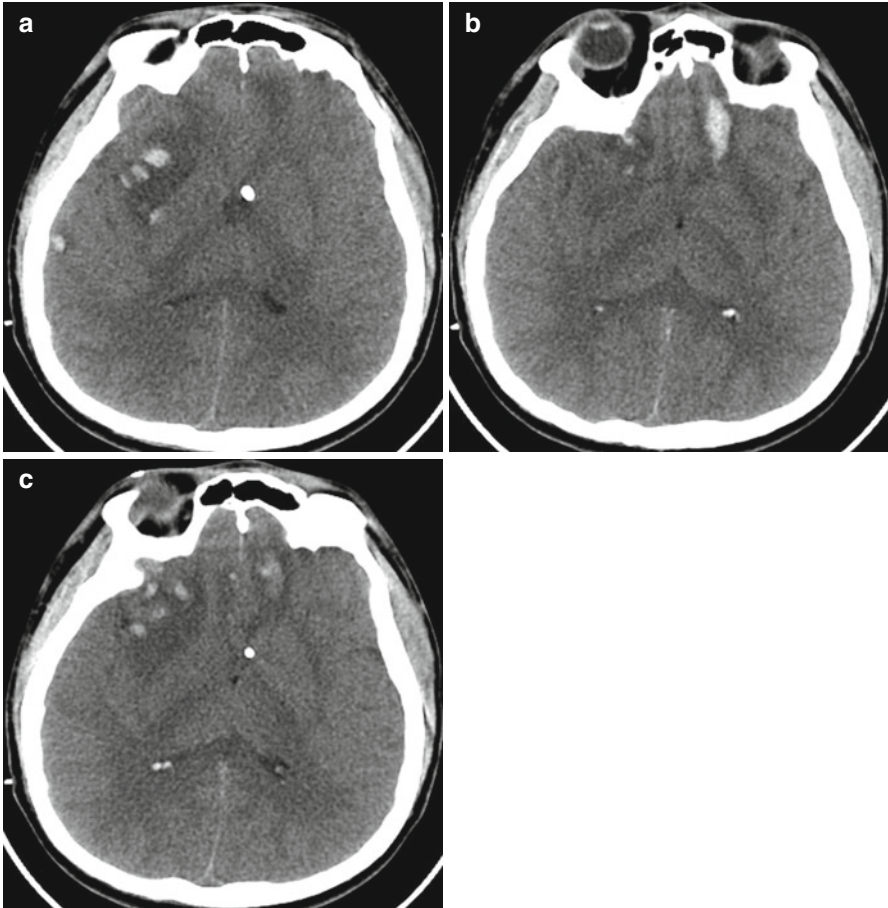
(a–c) Patient involved in a motor vehicle collision. Non-contrast enhanced computed tomography (CT) demonstrates hemorrhagic contusions anterior inferior frontal lobes as well as right temporal lobe. Note surrounding edema resulting in mass effect. A ventriculostomy catheter is in place
